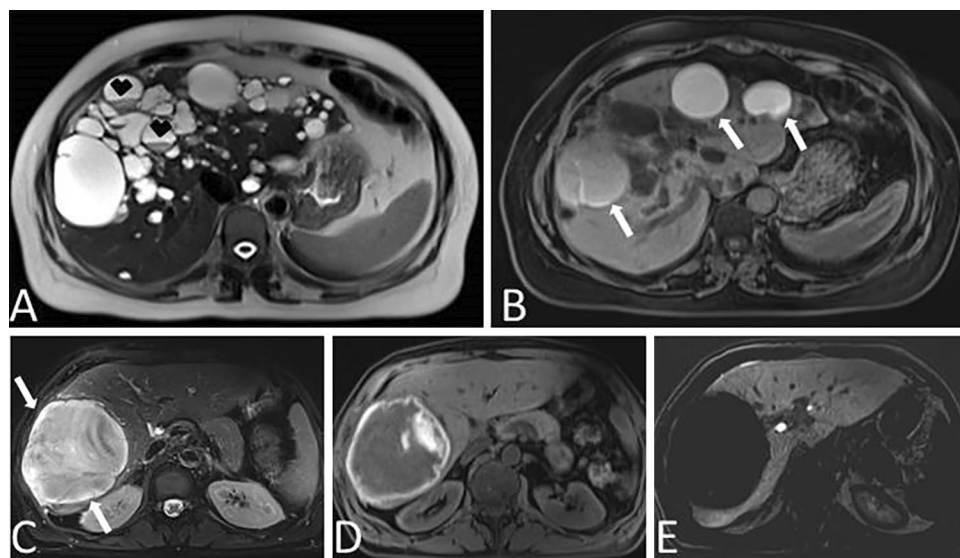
Hemorrhagic liver cysts in two different patients. A 57-year-old female patient with known polycystic liver disease presenting with jaundice and recent-onset right upper quadrant pain. Axial T2W MR image shows multiple liver cysts and two cysts with internal fluid–fluid levels (arrowheads), suggestive of hemorrhage. B Axial precontrast T1W MR image demonstrates the hemorrhagic liver cysts (arrows) in the same patient as in A. C–E 50-year-old male
